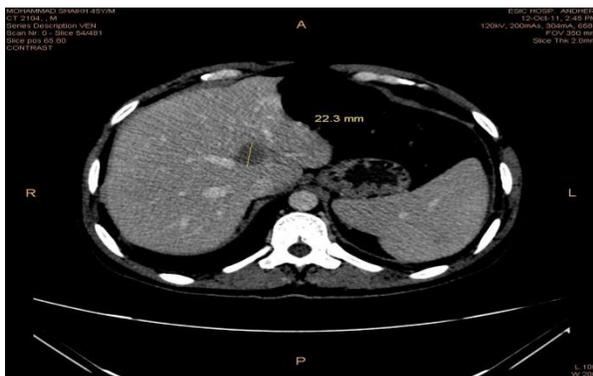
CT Scan liver showing well defined hypodense, hypoenhancing focal lesion in segment V of right lobe suggestive of metastasis
